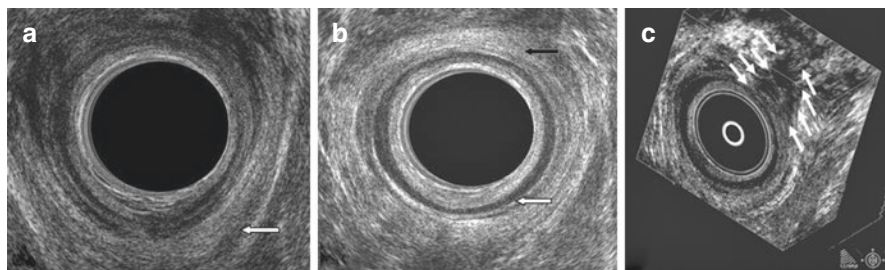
(a) Endoanal scan demonstrating the U-shaped puborectalis muscle, which attaches to the pubic rami anteriorly. (b) Endoanal scan demonstrating the internal anal sphincter (*white arrow*) and the external anal sphincter (*black arrow*). (c) Three-dimensional endoanal ultrasound demonstrating the circumference/width as well as length of the anal sphincter defect. (Reproduced from [13] with permission from British Institute of Radiology)
